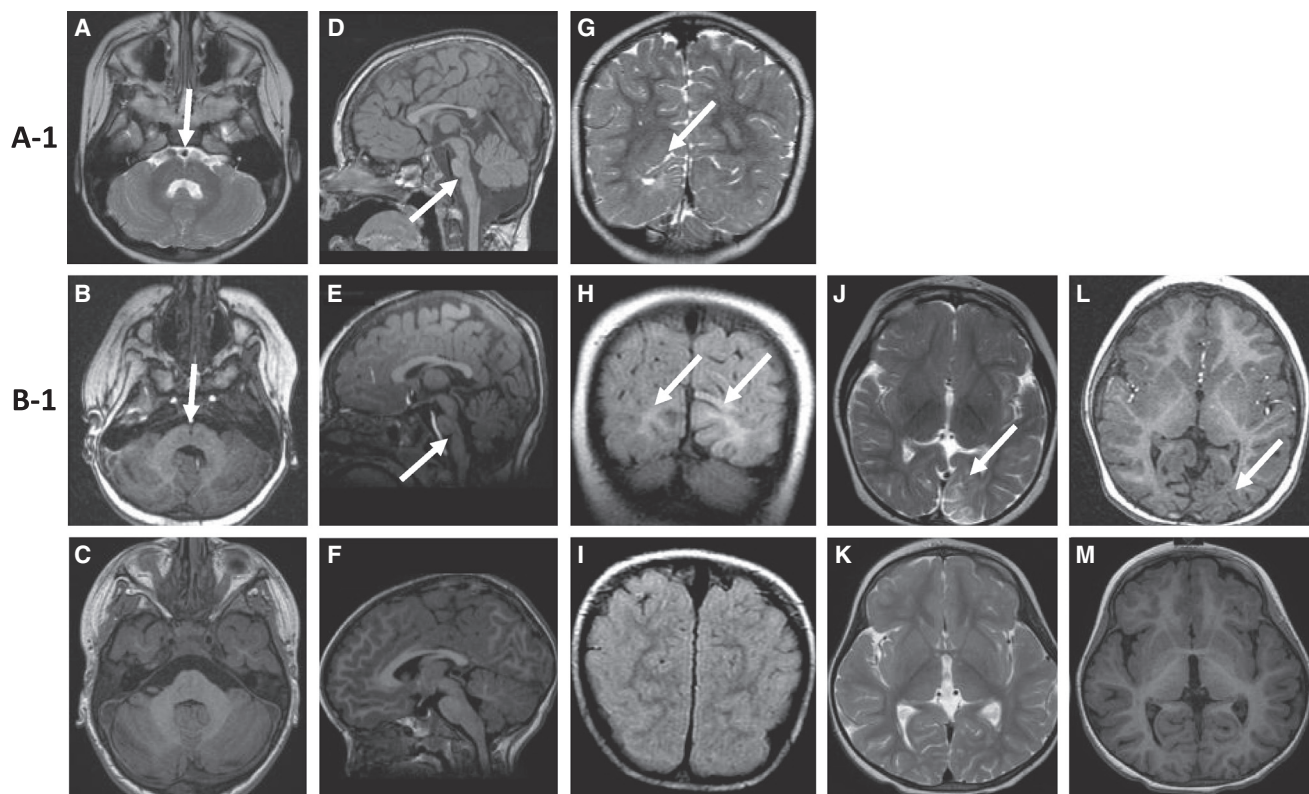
Brain MRI of Individuals with Mutations in *DOCK7*
